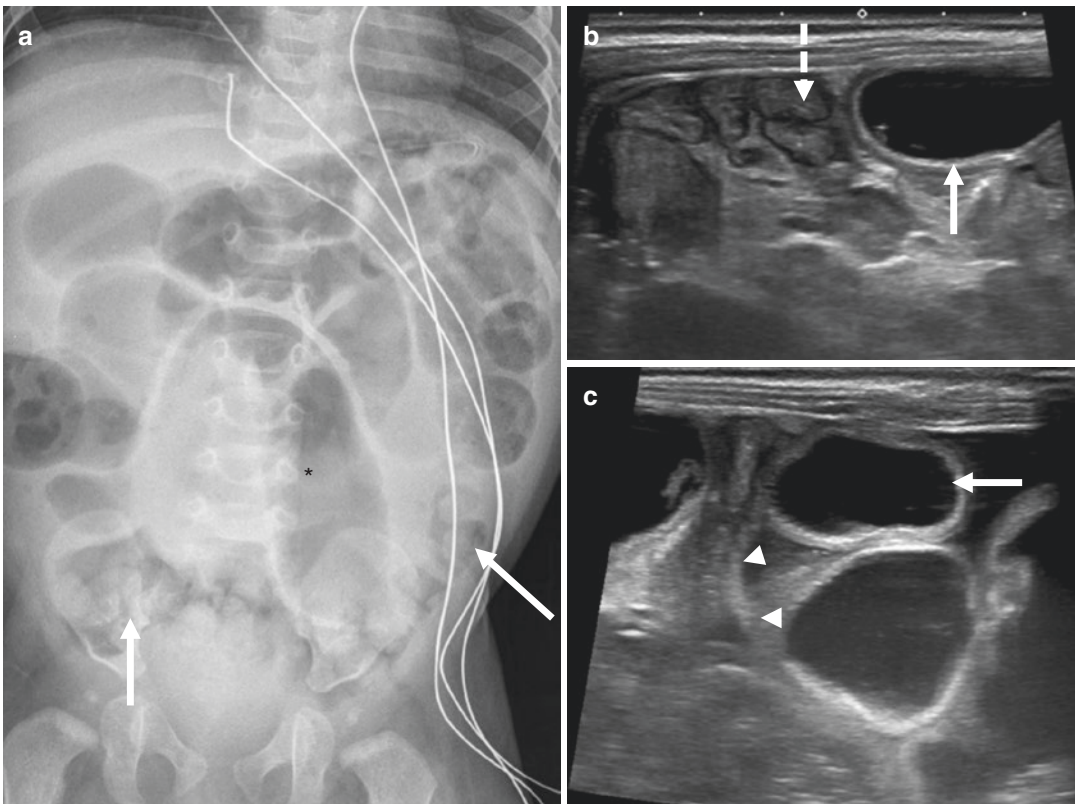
Mechanical obstruction in an 8-month-old boy with history of laparotomy for irreducible intussusception. (a) Supine abdominal radiograph shows dilated bowel loops in the umbilical region (*asterisk*) and paucity of gas in colon (*arrow*). (b, c) Abdominal ultrasound with high-frequency probe images shows dilated small-bowel
